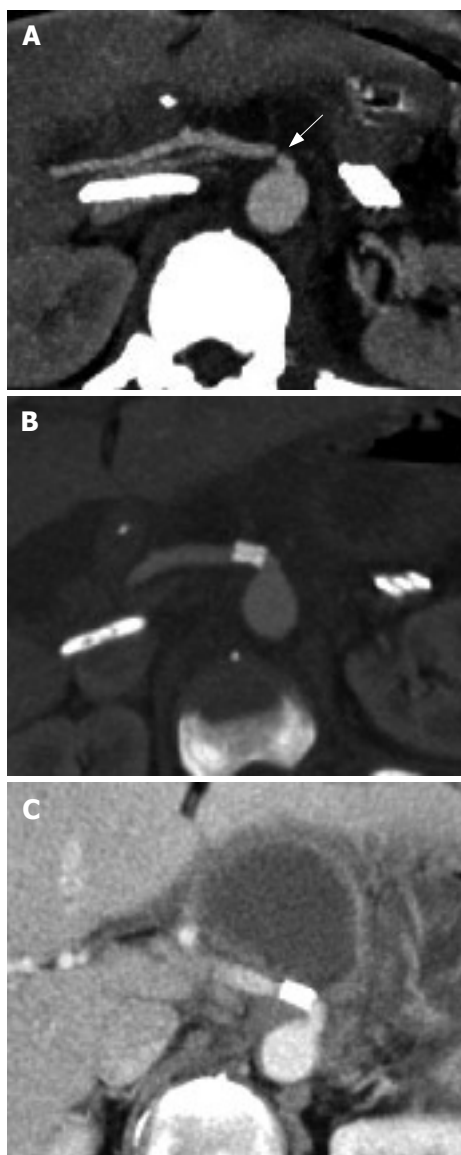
CT scan 12 h after operation showing severe stenosis of hepatic artery-celiac reconstruction (A), good result of the procedure confirmed by CT after endovascular treatment (B), and a symptomatic pseudocyst in the epigastric region three months later (C) which was successfully treated by percutaneous drainage, rest and antibiotics.
